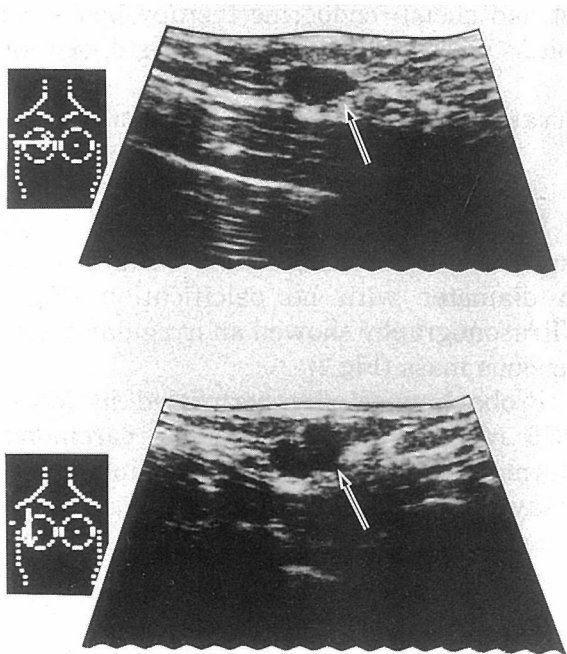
Ultrasonogram revealed an irregular heterogeneous mass (arrow).
